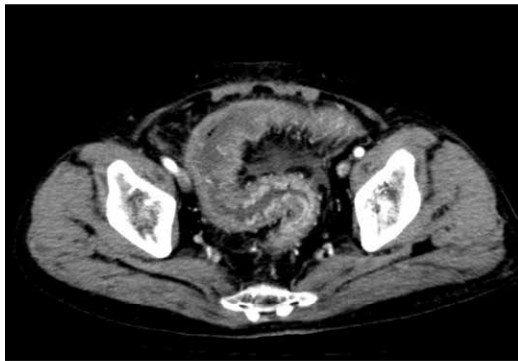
Abdominal enhanced computed tomography performed on day 6 postadmission: prominent edema and thickening of the entire colorectum.
